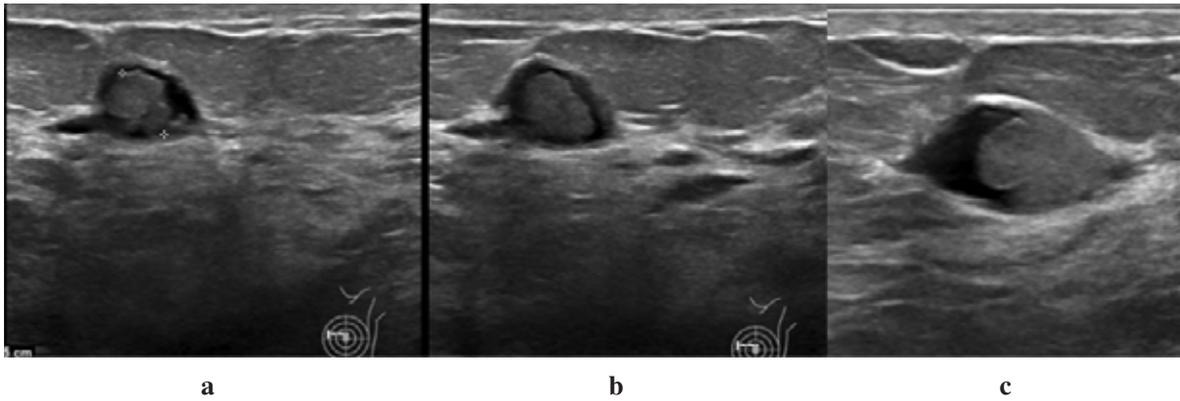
(a,b,c). Intraductal papilloma. Ultrasound images reveal a dilated lactiferous duct occupied by a solid mass with crenulated contour.
